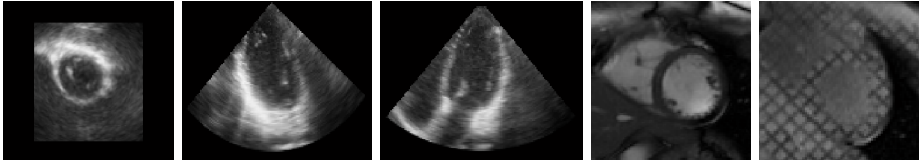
The ED frame of echocardiography and MRIs of one subject. The first three images are orthogonal view of the echocardiography. The last two images are short axis ROIs from the cine MRI and the tagged MRI images.
